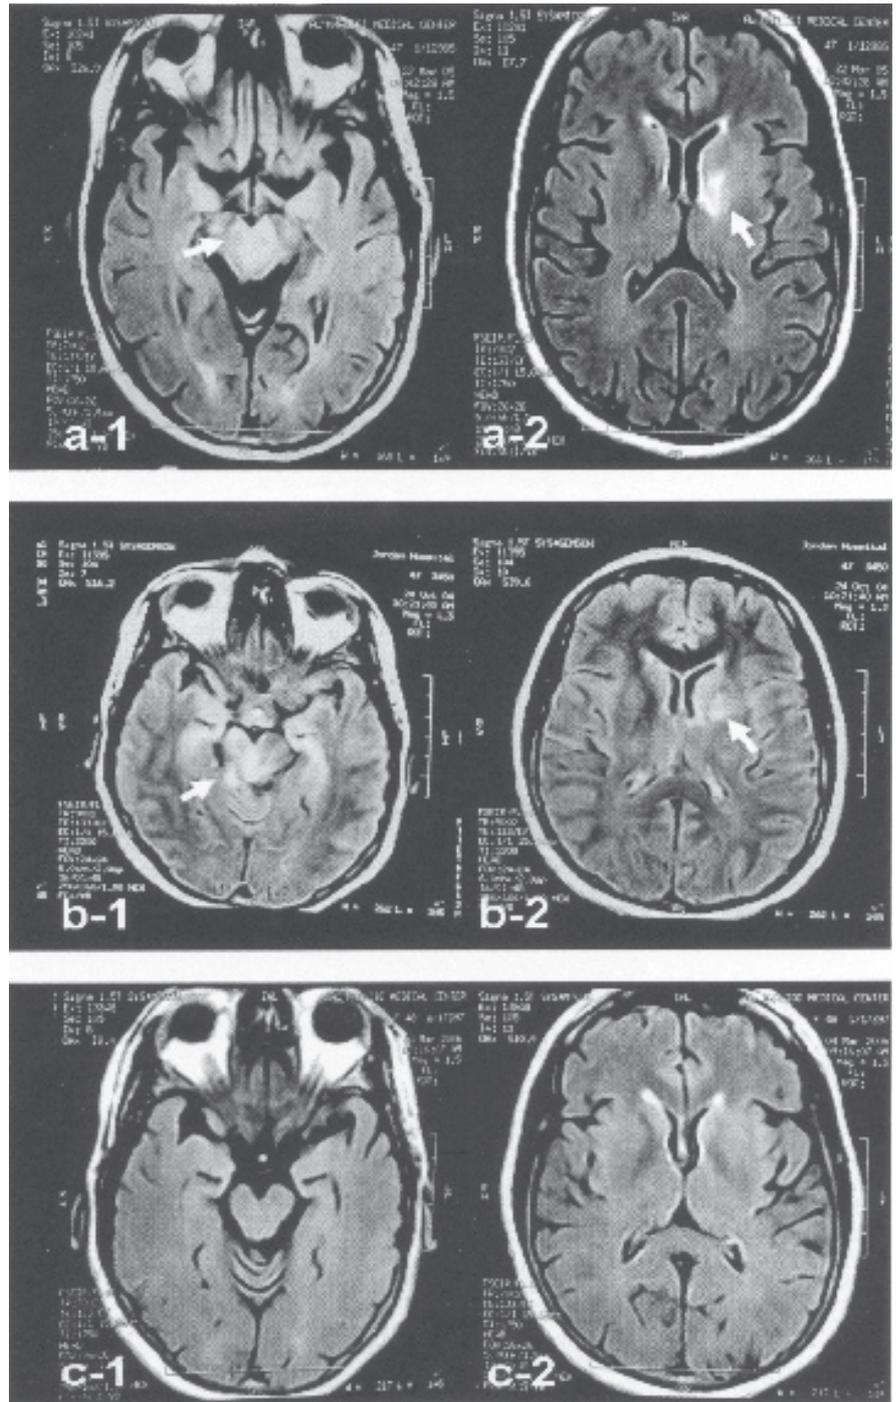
(a-1, a-2) Brain MRI 2004: patchy small hyperintense lesions seen in the brain stem, mainly at the lower mid-brain, right thalamus and left basal ganglia. (b-1, b-2) Brain MRI 2005: evidence of abnormal signal lesions seen in the brain stem and left deep parietal and peri-ventricular regions. (c-1, c-2) Brain MRI 2006: hyperintensity of the deep peri-ventricular white matter only, seen adjacent to the frontal horns of both lateral ventricles; other brain tissue and structures normal; no contrast uptake by brain tissue could be depicted.
